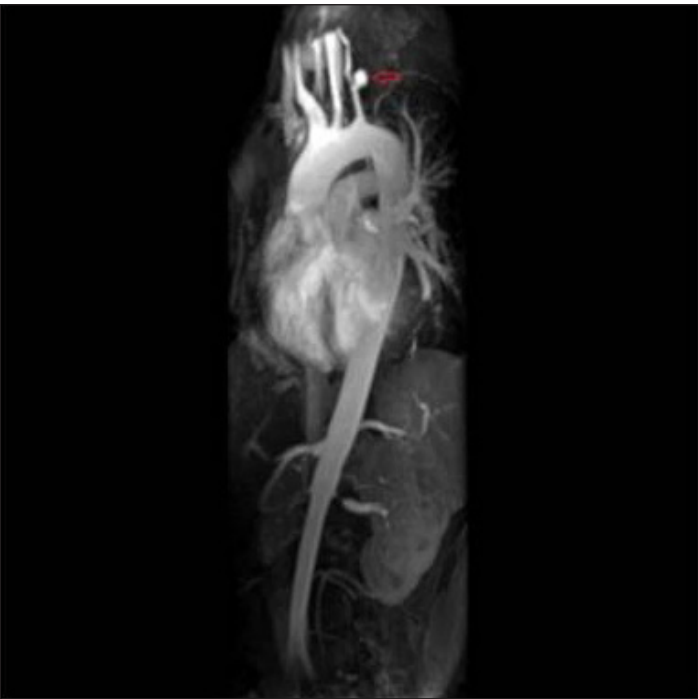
CT angiography showed complete stenosis of the left subclavian artery (Case 3).
